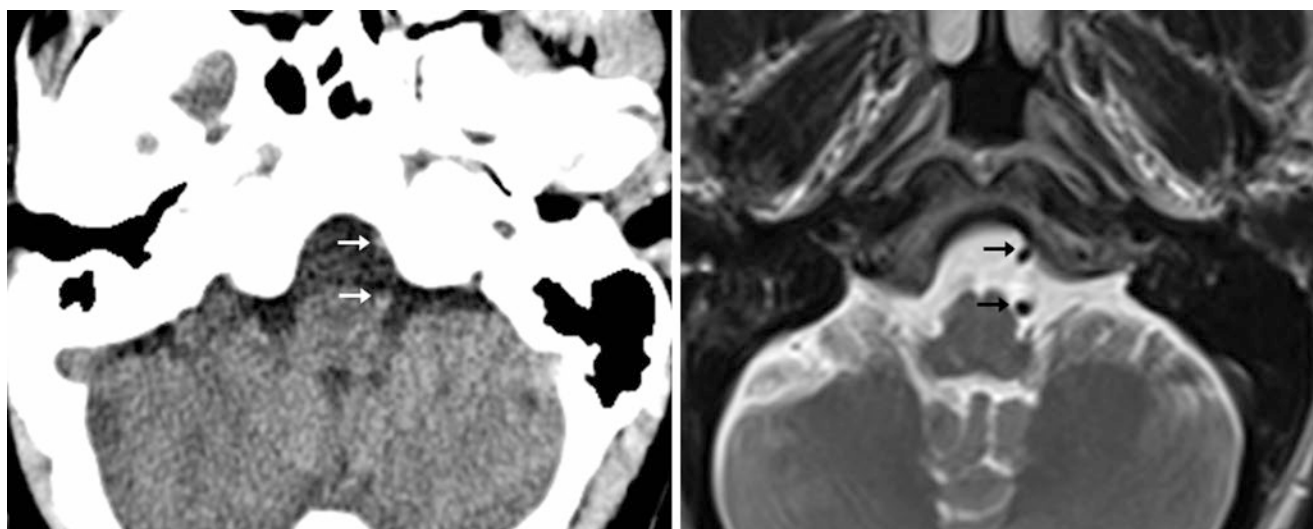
55-year-old with axial nonenhanced CT (left) and T2WI MRI (right). Both VAs appear on the same side (arrows), indicating at least moderate tortuosity, without frank ectasia. This case is an example
